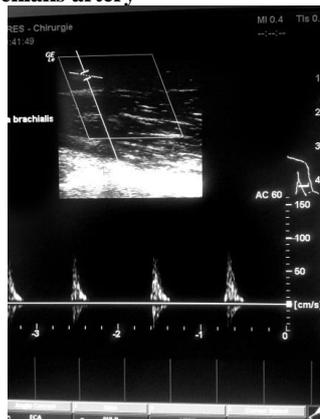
Postoperative Doppler ultrasound showing an open right brachialis artery
